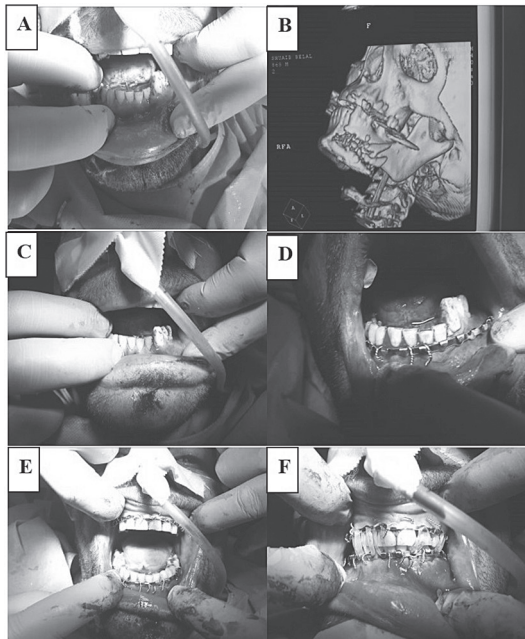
A- Preoperative view, B- 3D of CT skull, C- Reduction of fracture mandible, D- Lower arch bar was placed, E- Upper arch bar was placed, F-Intermaxillary fixation (IMF)
